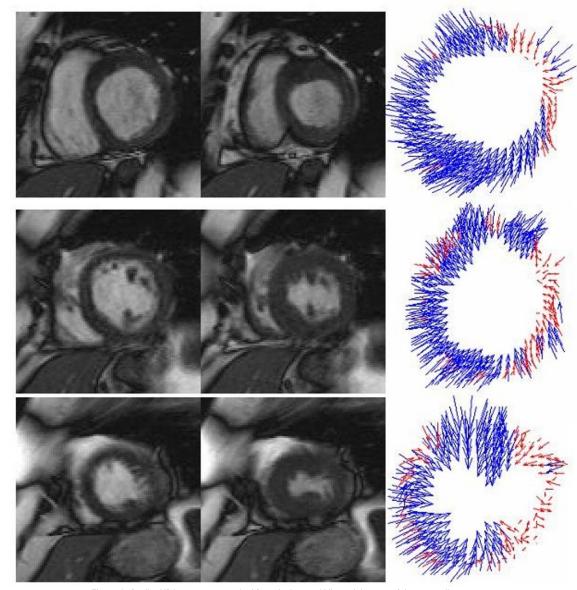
Cardiac MR images were acquired from the base, middle, and the apex of the myocardium. MSSM matched the end diastolic and the end systolic images, producing disparity maps. Cardiac motion was derived from the disparity maps and shown as small arrows. The direction and the length of the arrow shows the direction and distance of cardiac motion. A threshold can be manually defined (5 mm in this study) to differentiate healthy and unhealthy cardiac motion. The arrows with a length greater than the threshold are shown in blue, indicating the normal cardiac motion. Similarly, the arrows shorter than the threshold are shown in red, suggesting abnormal cardiac motion.
